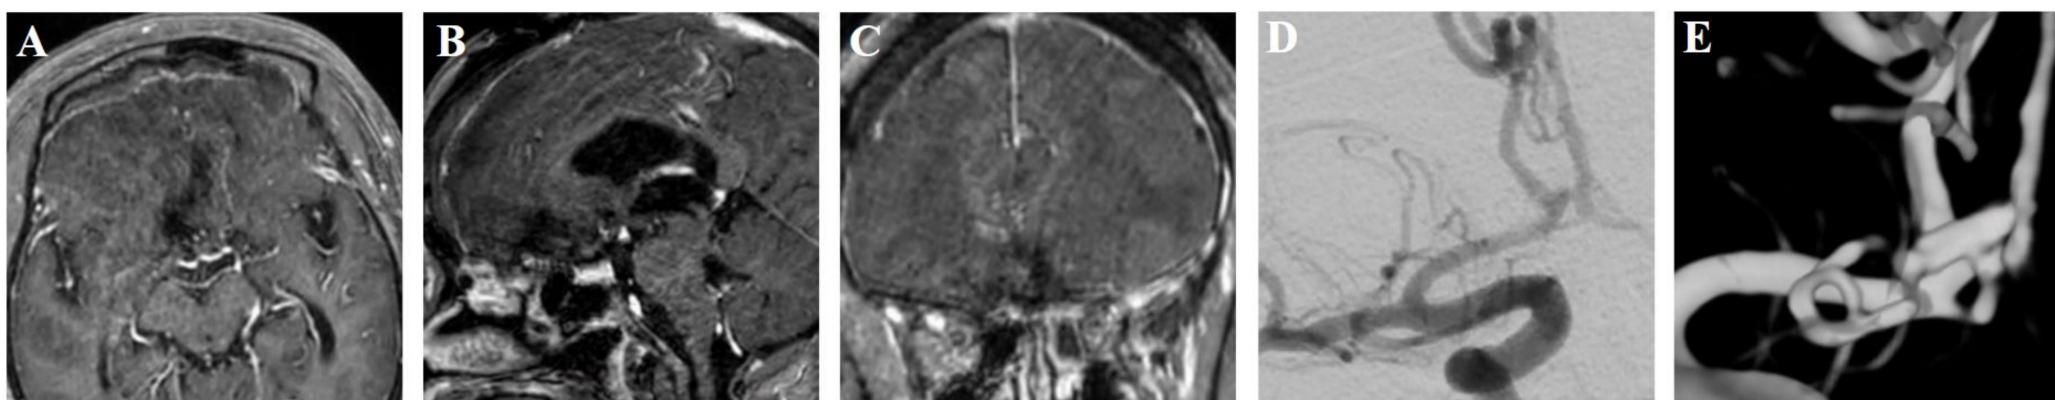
A-C, Postoperative brain MRI demonstrates gross total resection of the anterior cranial fossa lesion. D-E, Postoperative cerebral DSA confirms complete aneurysm obliteration by clip.
